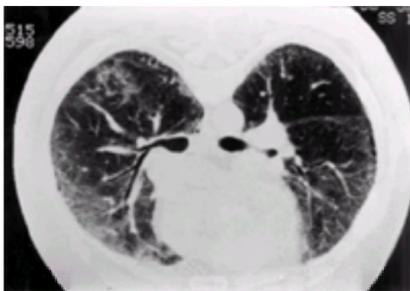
Prone, high-resolution CT at the level of the carina. Diffuse parenchymal opacification in a subpleural distribution. This pattern is seen during the desquamative phase of fibrosing alveolitis.
